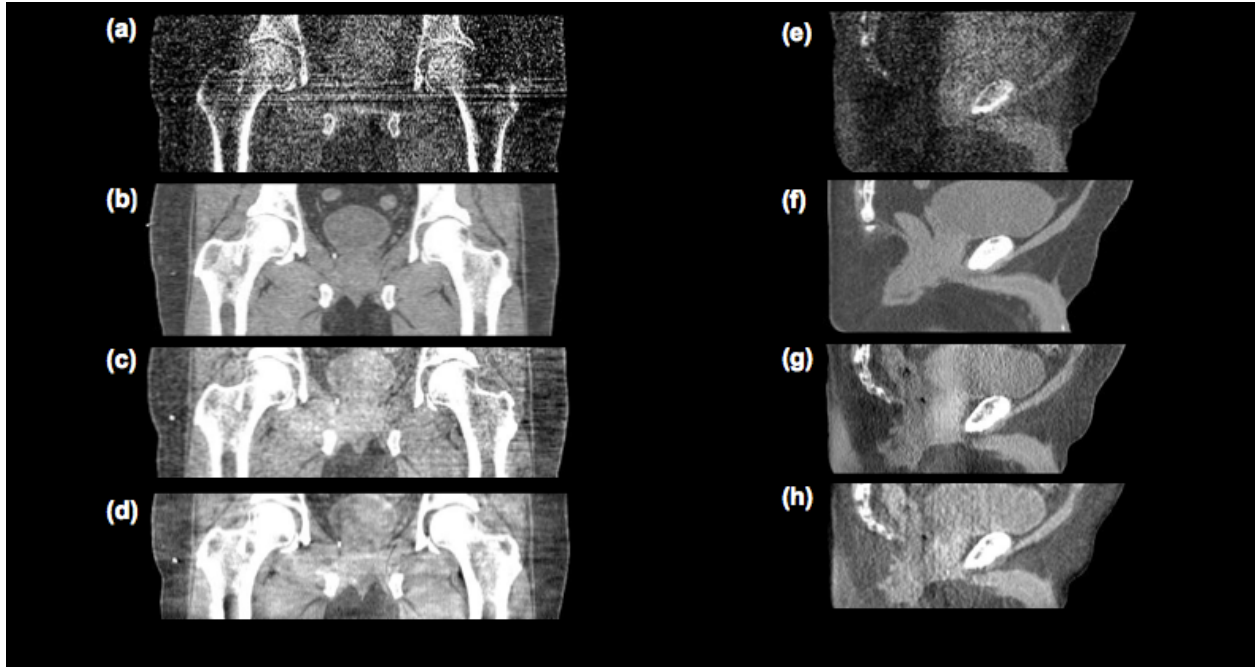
First example of successful shading corrected CBCT images (Patient A) in coronal and sagittal views.
